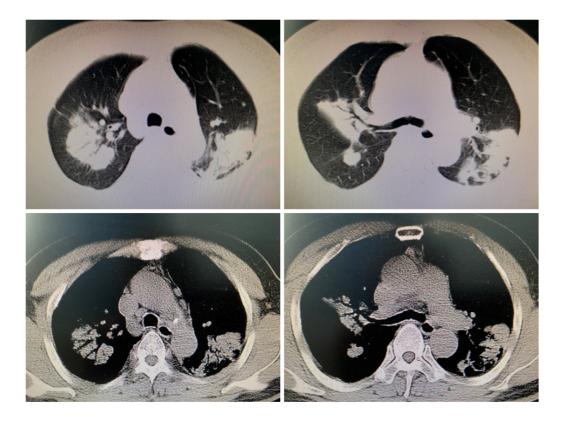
Lung computed tomography showing multiple lung lesions, multiple small nodules with blurred boundaries in both lungs, and cystic changes.
